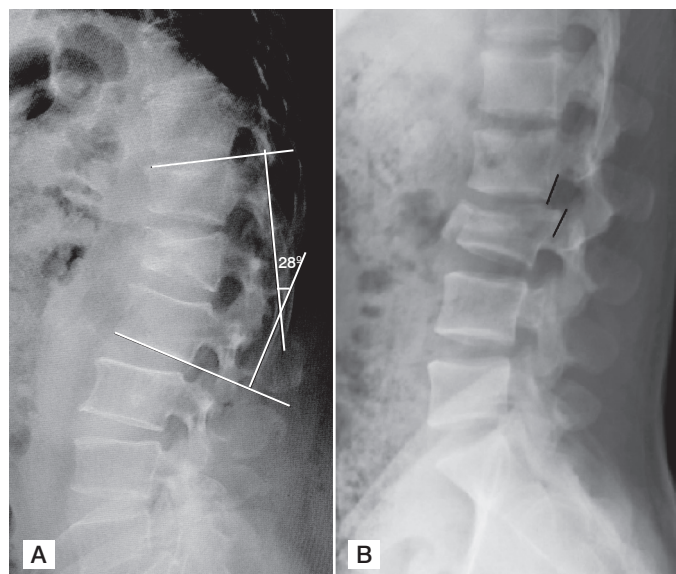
(A) Lateral radiograph showing the Cobb angle, (B) Lateral radiograph showing vertebral translation.
